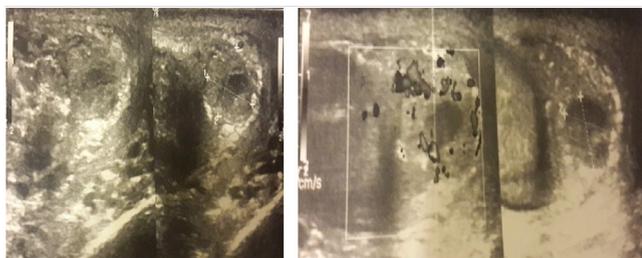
Ultrasound images of the epididymal mass
